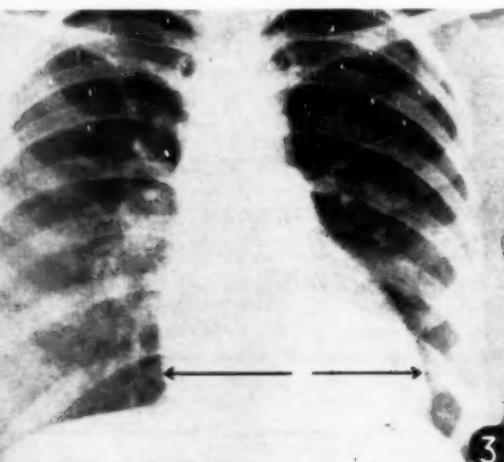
(Case 24): X-ray showing evidence of marked left ventricular enlargement in a pregnant woman of 18 years. LV=Left ventricle; RV=Right ventricle.
